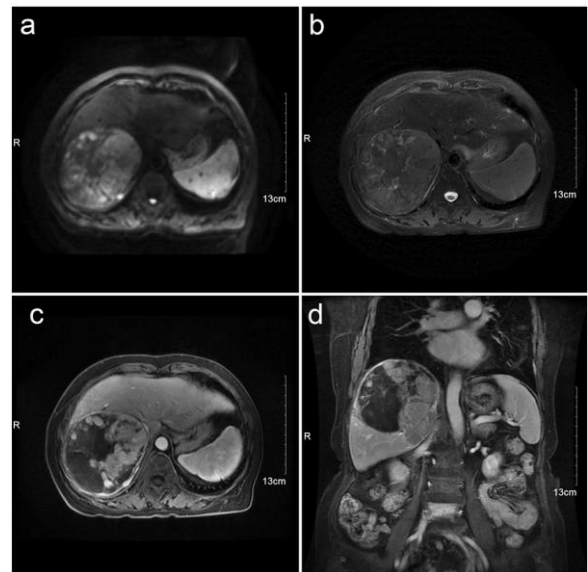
Patient A receiving cTACE treatment. Liver contrast-enhanced MRI images 4 months after the second session of cTACE, showing the progressive growth of the tumor.
